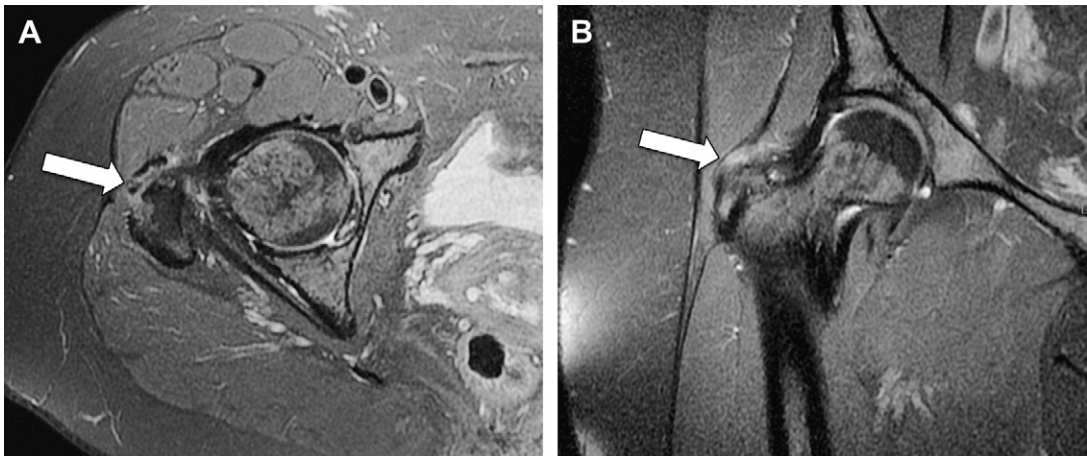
(A) Axial fat-saturated T2-weighted image demonstrating gluteus minimus tendinosis at its insertion on the anterior border of the greater trochanter (arrow). (B) Coronal fat-saturated T2-weighted image in same patient, demonstrating the abnormal high signal of gluteus minimus tendinosis (arrow).
